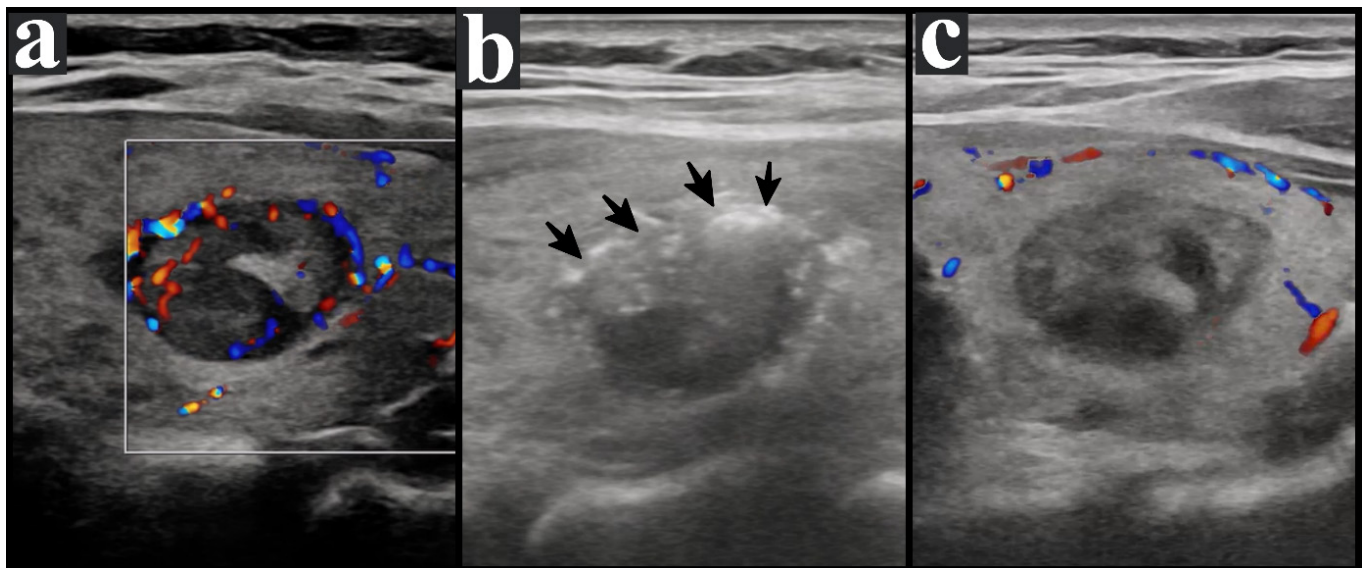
A 48-year-old woman with intrathyroidal parathyroid adenoma in the left thyroid lobe was confirmed by scintigraphy and fine-needle aspiration parathyroid hormone washout test. Figure A shows the internal vascularization of the parathyroid adenoma on preprocedural Doppler ultrasonography. Figure B shows immediate changes, such as echogenic gas bubbles (arrows), and Figure C shows the absence of internal vascularization of the parathyroid adenoma on postprocedure Doppler ultrasonography.
